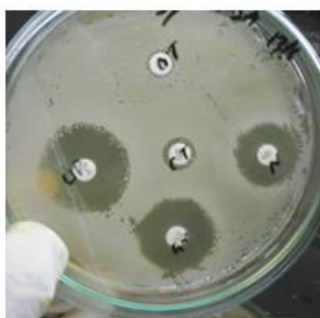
Antibacterial susceptibility test of *Staphylococcus aureus* on Muller Hinton Agar resistant to Oxytetracycline (OT), colistin Sulphate (CT), and Susceptible to Ciprofloxacin (CIP), Gentamicin (CN) and neomycin
